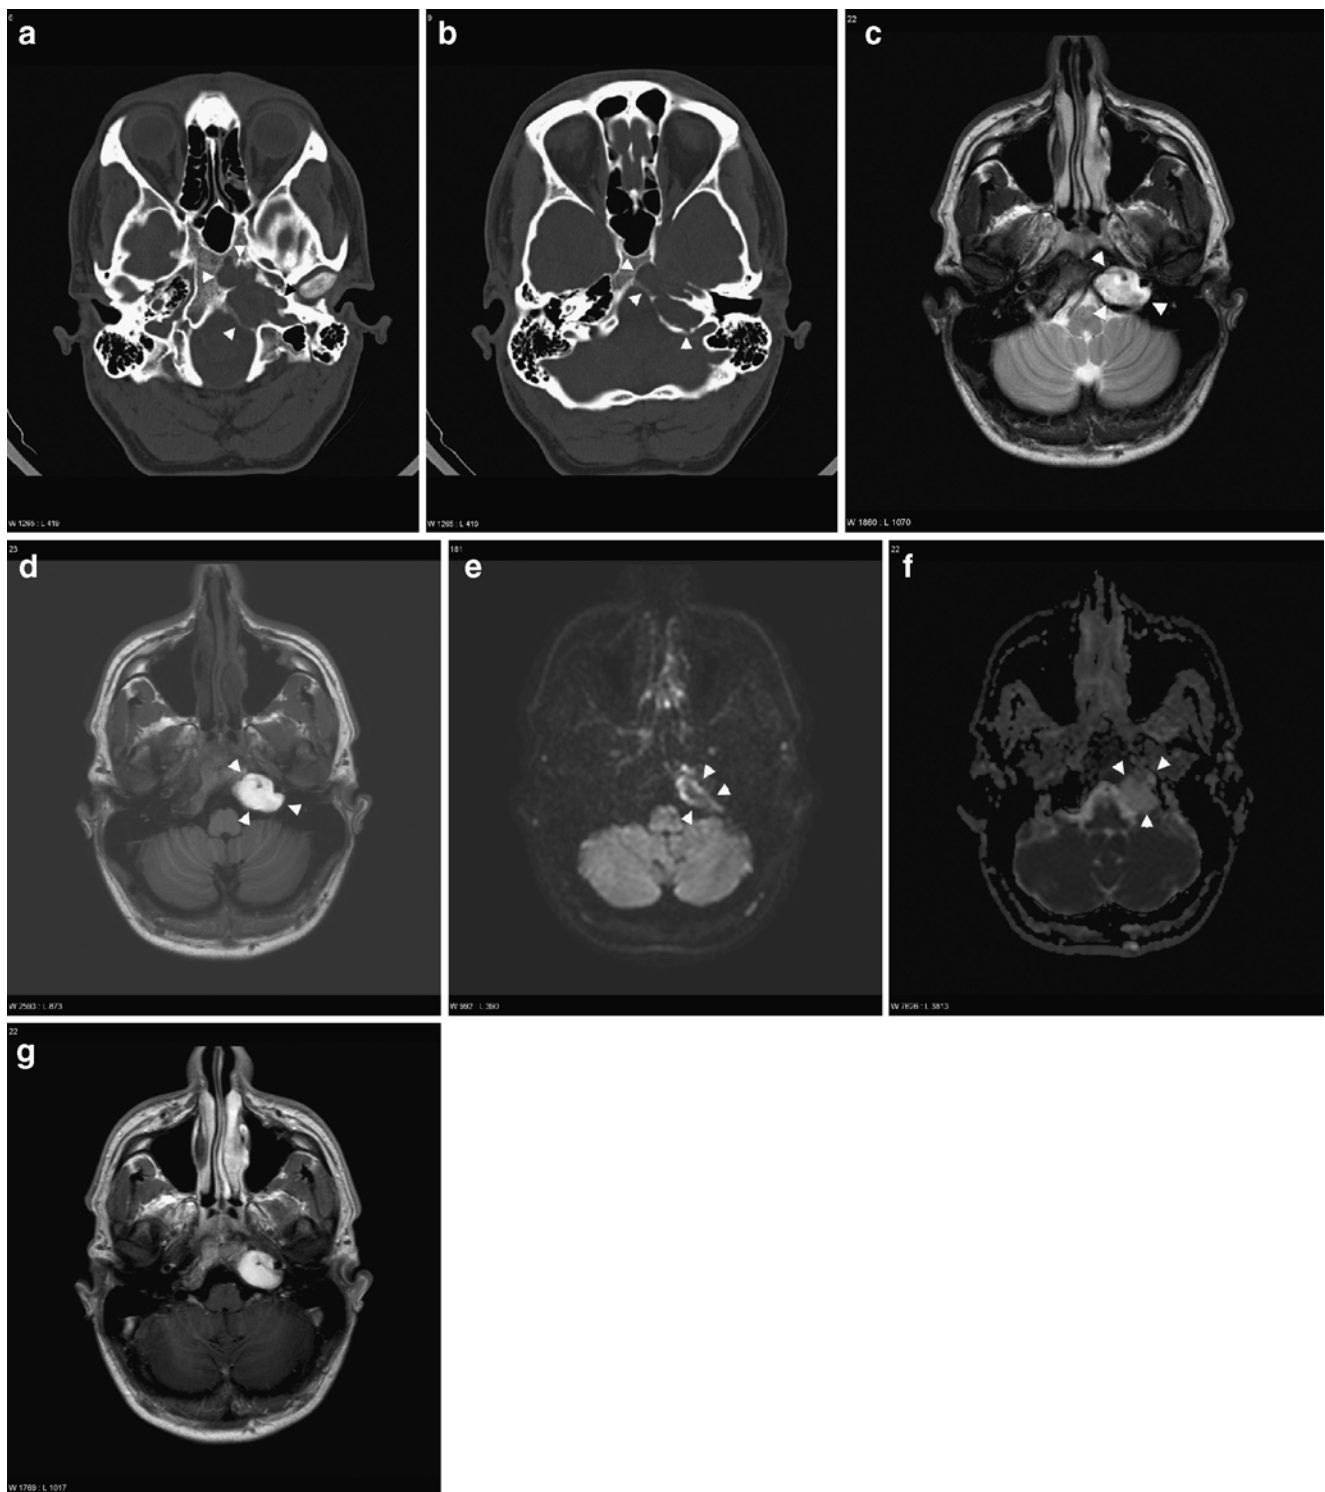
A 39-year-old female presenting with mixed hearing loss on the right side. a Axial CT scan of the right temporal bone at the level of the vestibule, malleus head, and incus body. A well aerated middle ear and mastoid can be noted. There is aeration of the petrous bone medially to the otic capsule (*large arrowhead*). Note the homogeneous ossification of the petrous apex (*small arrowheads*). b Axial CT scan of the left temporal bone at the level of the superior semicircular canal. Note the homogeneous nodular density in the apex of the petrous bone (*asterisk*). There is a small triangular air density posterior to it (*small arrowhead*). This small air density is suggestive of a near total opacified aerated petrous apex with fluid and/or inflammation. c Axial 4-mm-thick TSE T2-weighted image through the posterior fossa at the level of the internal auditory canal. There is a nodular hyperintense lesion in the apex of the left petrous bone (*arrow*). Note that the lesion has a slightly higher intensity than CSF. d Axial 2-mm-thick post-gadolinium SE T1-weighted image at the level of the internal auditory canal. The lesion situated in the apex of the left petrous bone (*small*
